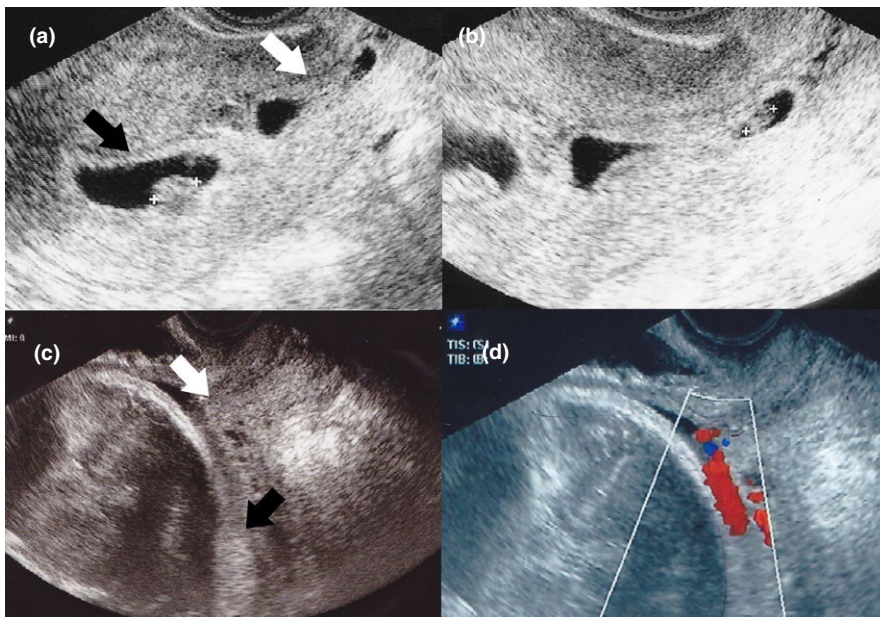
Ultrasonographic findings of the patient. (a) and (b) Transvaginal ultrasonography at 7-0/7 weeks of gestation. The gestational sacs in the uterus (black arrow) and cervical canal (white arrow) are shown. The plus signs indicate the fetus. The crown-to-rump lengths were 10.6 mm in the intrauterine pregnancy and 5.6 mm in the cervical pregnancy. (c) and (d) Transvaginal ultrasonography at 31-2/7 weeks of gestation. A lower edge of the placenta (black arrow) was 41 mm apart from the internal os of the uterus (white arrow). The presence of a blood flow that connected the internal os and the lower edge of the placenta was observed. No sign of placenta accreta was observed before the cesarean section
